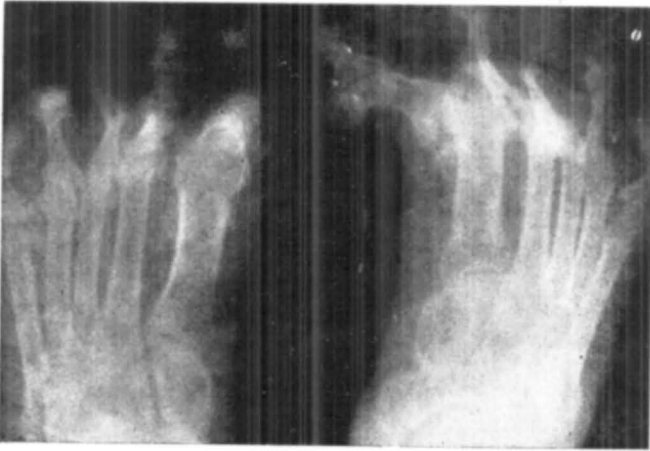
Showing X-ray of feet with mutilating arthropathy of small joints involving predominantly I.P. and M.P. joints of great toes, disorganisation, deformity and destruction of joints, osteolysis (Rt. side) bony ankylosis of great toes in case No. 2
